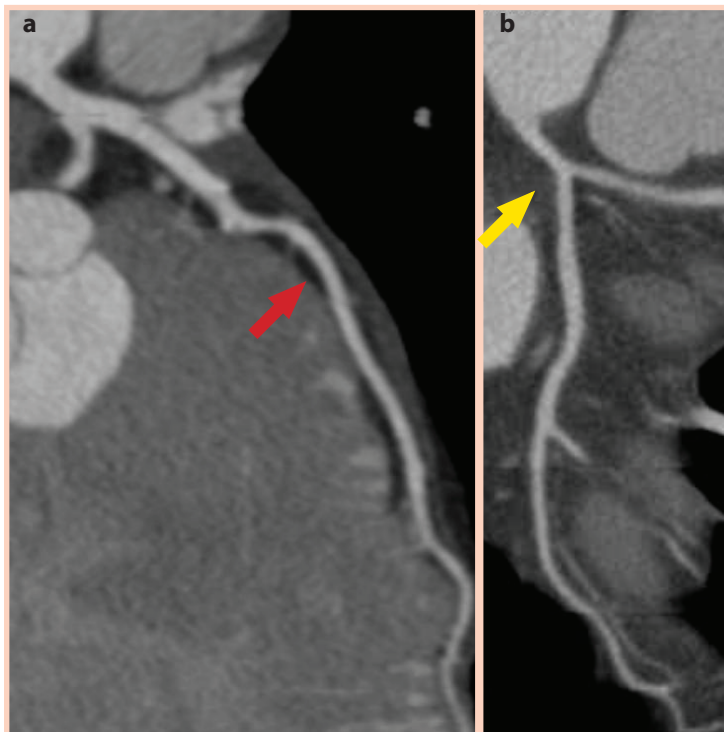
CT image of the left anterior descending artery (LAD) (a, red arrow) and the left circumflex artery (LCx) (b, yellow arrow).
